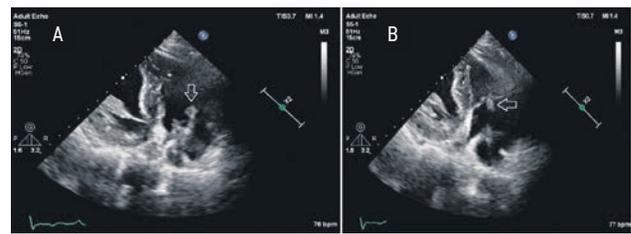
Echocardiography of patient B. Loose vegetation, fixed on the ventricular electrode near the tricuspid valve. Modified three-chambered apical section: A — Diastole, tricuspid valve open; B — Systole, tricuspid valve closed. Formation is fixed to the electrode; the cusps of the own tricuspid valve appear intact.
